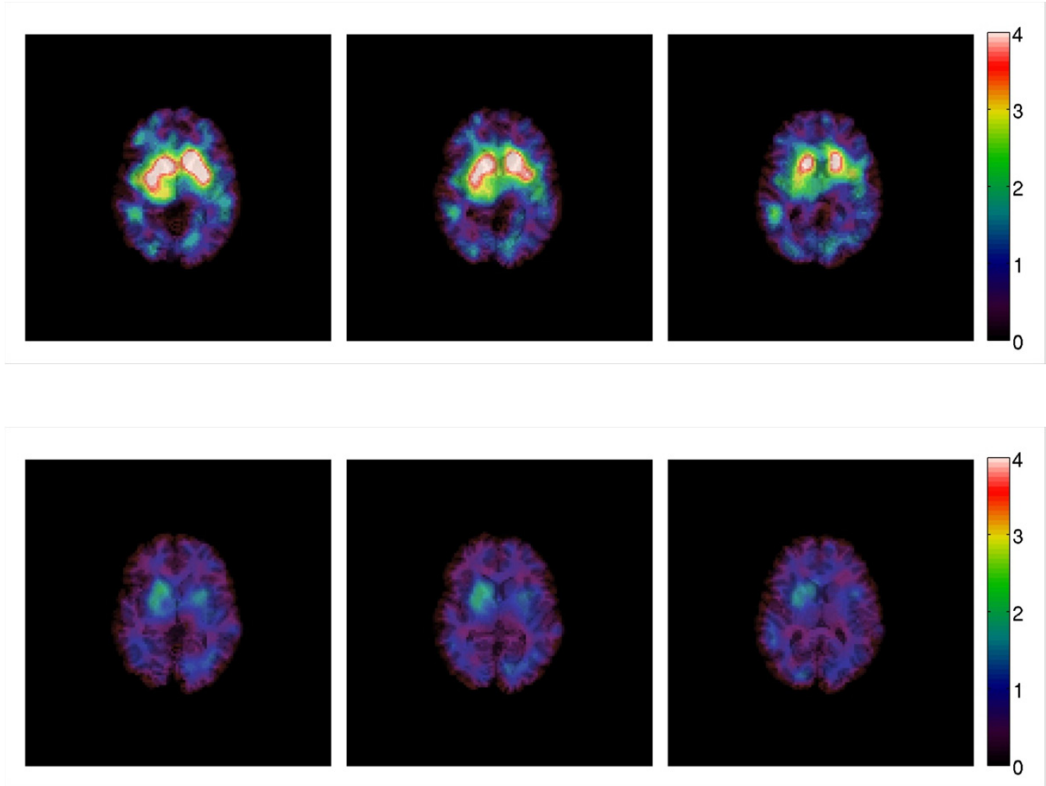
SPECT [ $^{123}\text{I}$ ]-IBZM of a patient before (top) and after (bottom) six weeks of treatment with the relatively selective dopamine  $\text{D}_{2/3}$  receptor antagonist amisulpride. The  $\text{BP}_p$  decreased significantly from baseline to follow-up.
